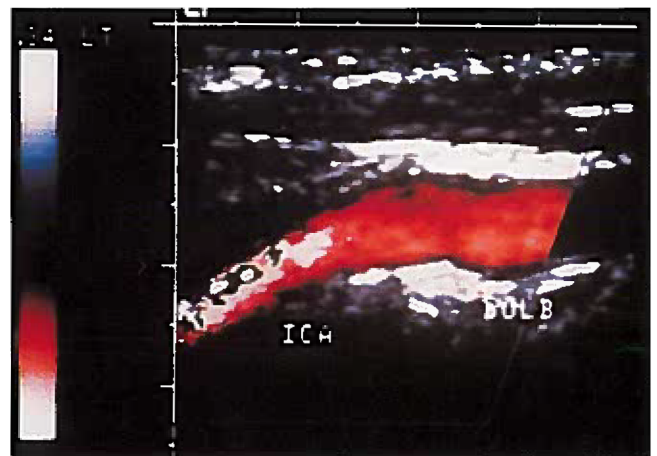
Transverse (A) and longitudinal (B) color Doppler sonograms of the left internal carotid artery obtained on December 31, 1991. The images demonstrate intraluminal thrombus with a freely moving tail located within the proximal internal carotid artery.
